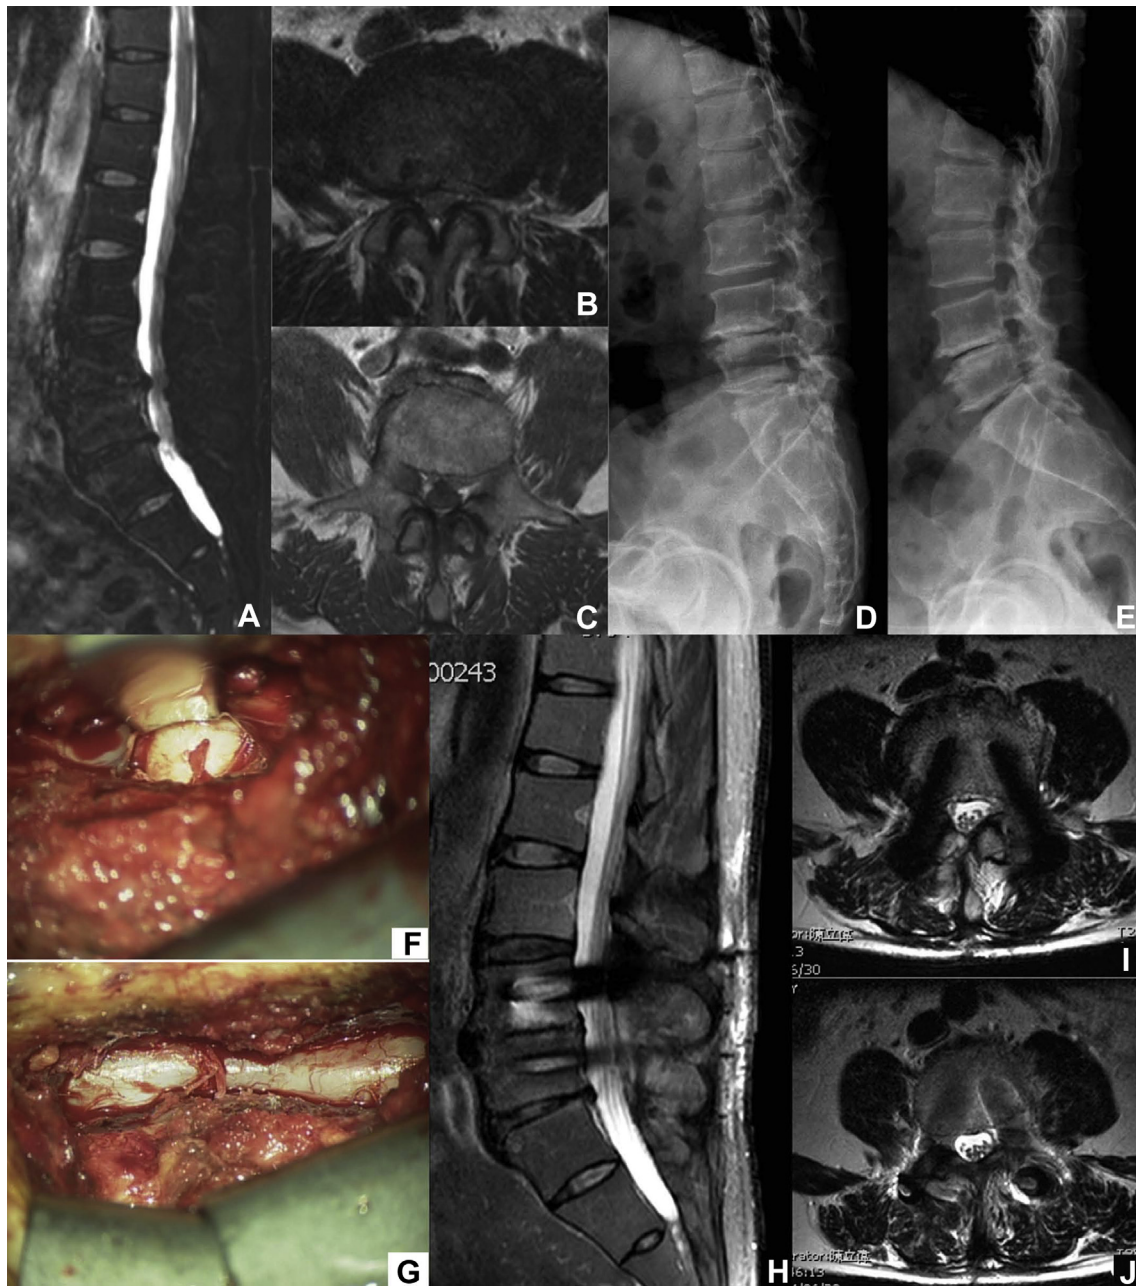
Example of a patient who underwent DTL implantation. (A–C) L-spine MRI showed bulging and R't extraforaminal protrusion of the L4-5–S1 disk with Modic type II endplate changes, causing severe spinal canal and bilateral neuroforaminal stenosis. (D, E) Dynamic view X-ray showed spondylotic change with spurs at the lumbar vertebrae and degenerative disk with a narrowed intervertebral space at the L4-5 and L5–S1 levels. (F) A herniated disk was noted. (G) Adequate decompression was achieved after unilateral hemilaminectomy with microdisctomy. (H–J) Follow-up MRI showed an enlarged spinal sac without neural compression in the sagittal and axial views. DTL = Dynesys top loading; MRI = magnetic resonance imaging.
